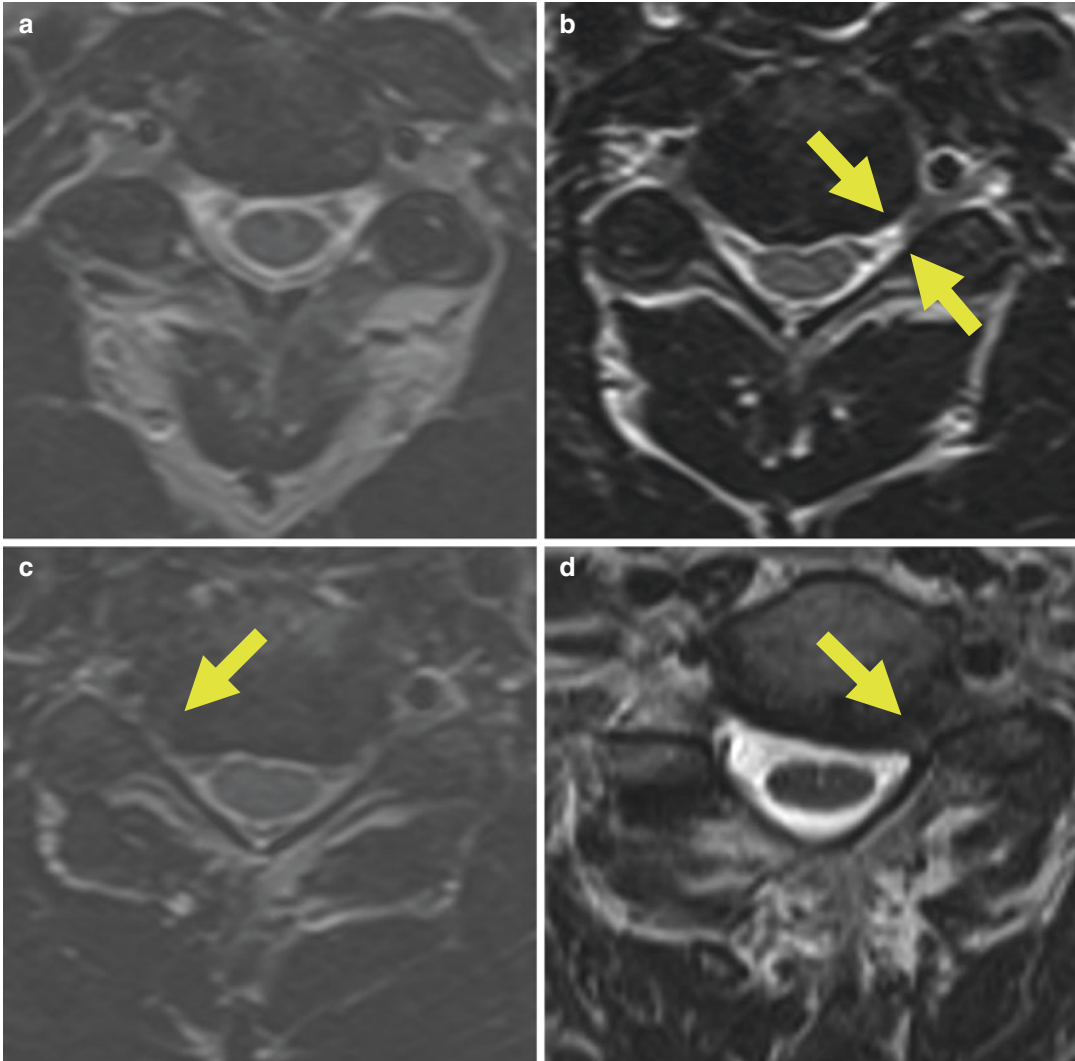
Axial T2-weighted images of the cervical spine. The normal neural foramina (a) are smooth with clean fat surrounding the exiting nerves. In mild stenosis (b), there is slight encroachment on this space (arrow). In
